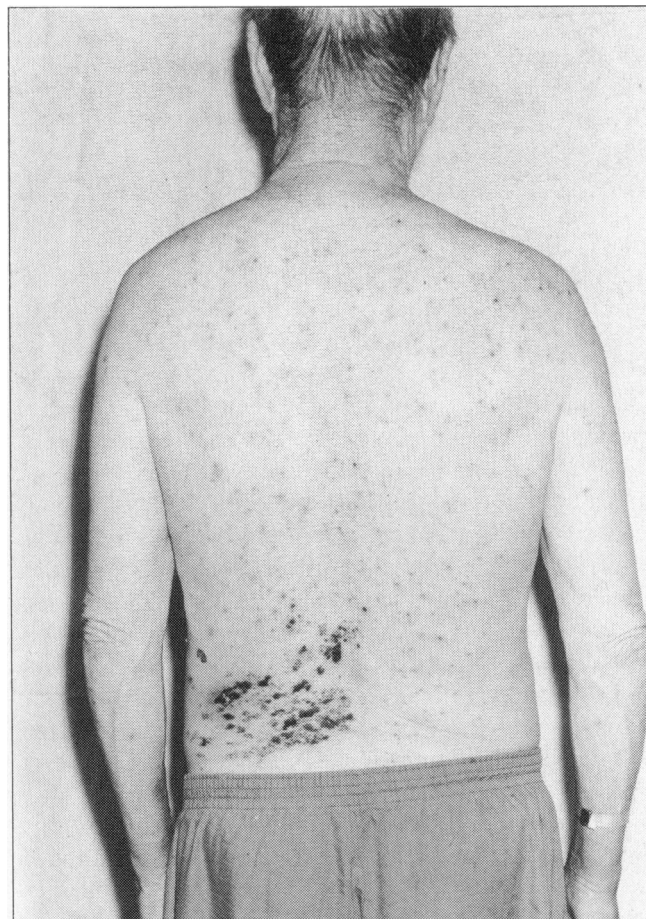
Disseminated herpes zoster after ultrasound therapy.
